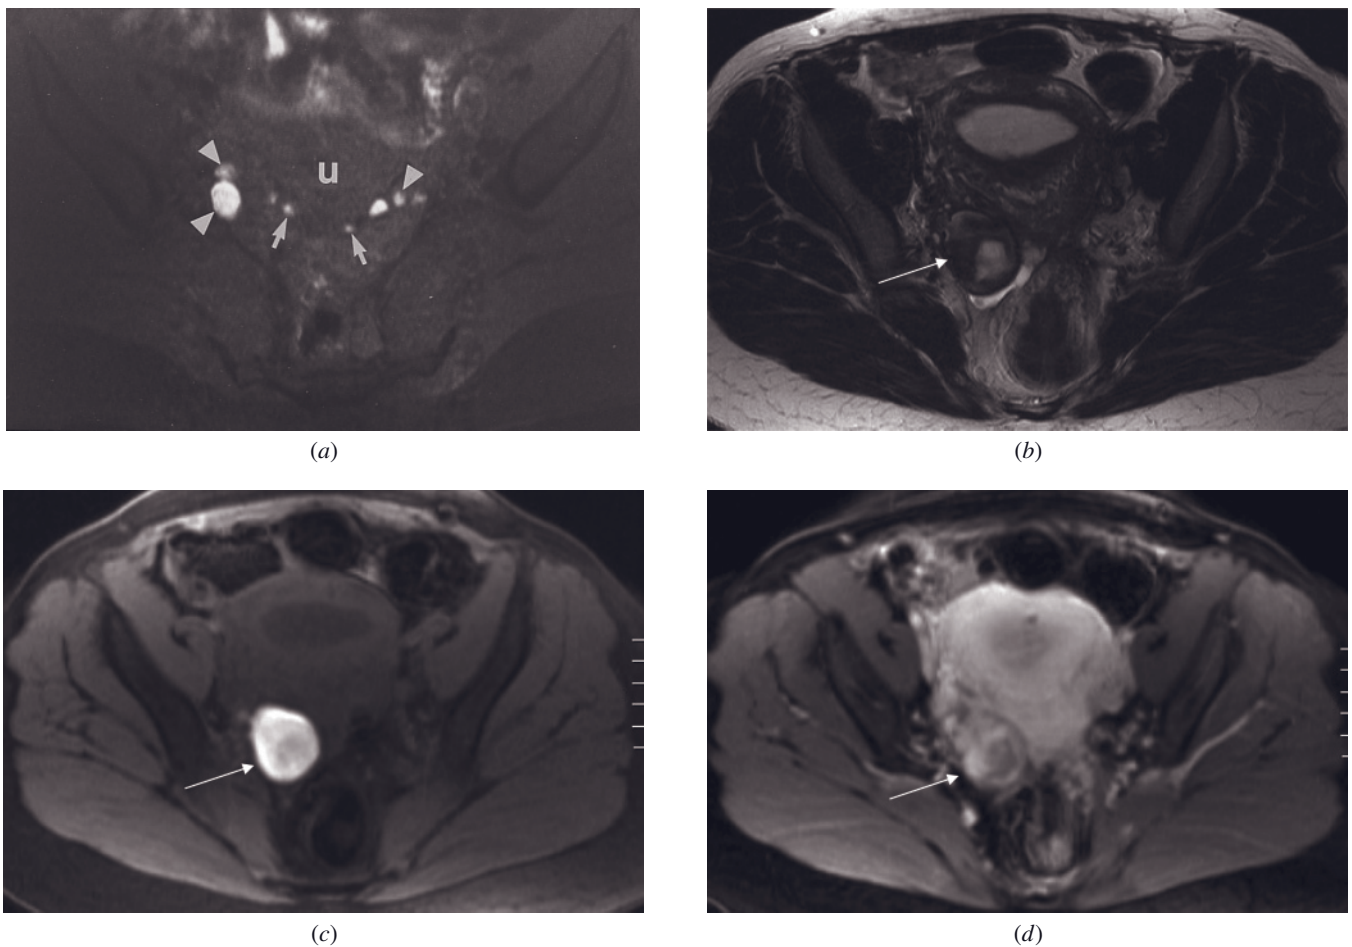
Endometriosis. T1-weighted fat-suppressed spin-echo image demonstrates high-signal-intensity foci of ovarian endometriomas (arrowheads) and smaller endometriosis implants adherent to the uterine serosa (arrows). T1-weighted fat-suppressed spin-echo or SGE or 3D-GE technique is the most sensitive and specific sequence for detecting the blood product-laden deposits of endometriosis. u, Uterus. (Reprinted with permission from Ascher SM, Agrawal R, Bis KG, Brown E et al. Endometriosis: appearance and detection with conventional, fat-suppressed, and contrast-enhanced fat-suppressed spin-echo techniques. *J Magn Reson Imaging* 5: 251–257, 1995.) T2-weighted high-resolution fast spin-echo (b), T1-weighted fat-suppressed SGE (c), and T1-weighted fat-suppressed interstitial-phase postgadolinium 3D-GE (d) images in another patient show a complex structure (arrows) composed of solid-cystic components and subacute stage blood products. The lesion does not demonstrate any enhancement and is located superior to the uterus and adjacent to the right adnexa. The diagnosis is consistent with endometrioma. There are also high-signal-intensity endometrial glands located in the myometrium, suggesting the presence of adenomyosis. Note free fluid located in the endometrial cavity and pelvis.
